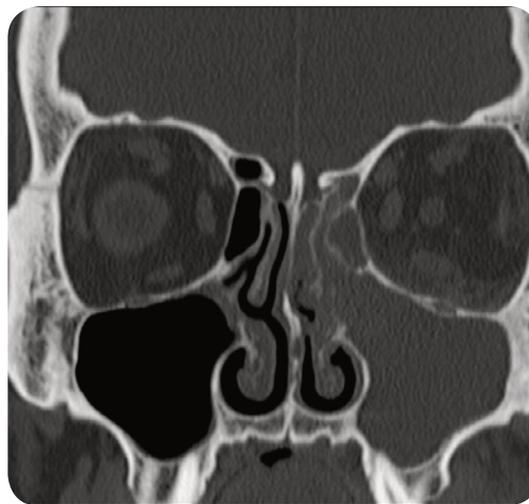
A CT scan of the head in the coronal plane demonstrating left maxillary sinusitis.
